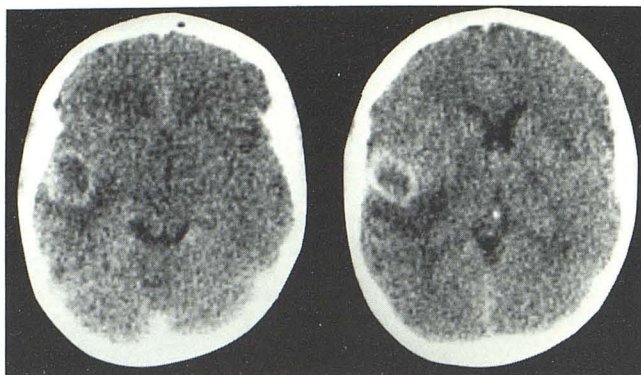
Brain abscess in 17-year-old man with known tricuspid atresia, atrial septal defect, and prior palliative Glenn and modified Pott procedures who was seen with left frontotemporal headache, episodic right facial and right arm numbness, and lethargy. Contrast-enhanced CT reveals superficial left superior temporal gyrus ring blush with thinner deep wall, subjacent edema, and mild mass effect, consistent with abscess.
